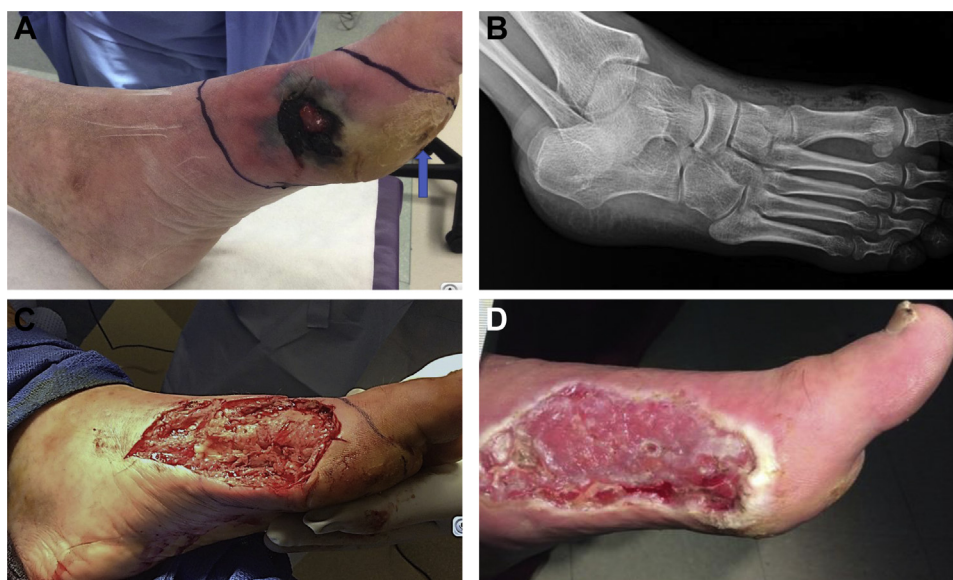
A, Preoperative image of left foot demonstrating complex diabetic soft tissue infection on the medial aspect with evidence of chronic callus (*blue arrow*) secondary to sensory neuropathy. B, Plain radiograph taken preoperatively demonstrating soft tissue emphysema and no obvious bony involvement. C, Intraoperative photo after debridement of skin, soft tissue, muscle, and tendon. D, Postoperative photo of nearly healed wound 4 to 6 weeks after initial debridement with interval skin grafting.
